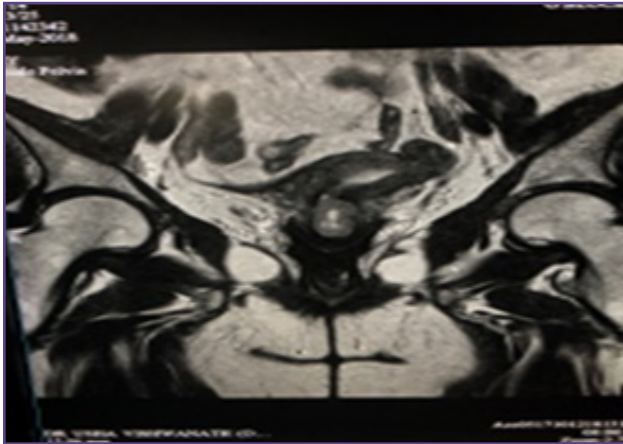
MRI image showing heterogenous mass in the endometrium.
